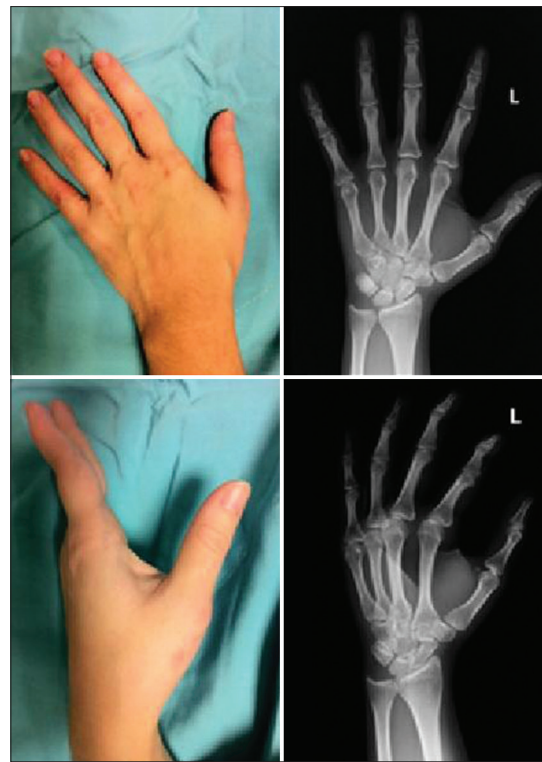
Postreduction pictures and radiographs of the left hand
